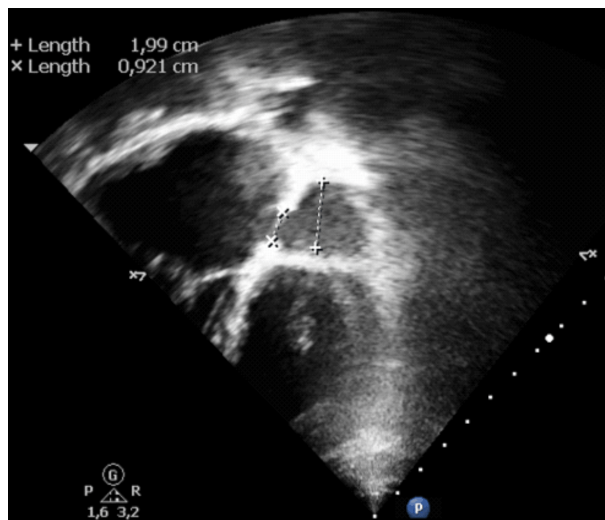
Postoperative transthoracic echocardiography of the reconstructed coronary sinus with patching of the roof of the coronary sinus in the patient with Raghbi syndrome. The persistent left superior vena cava was extracardiac connected to the right atrial appendage.
